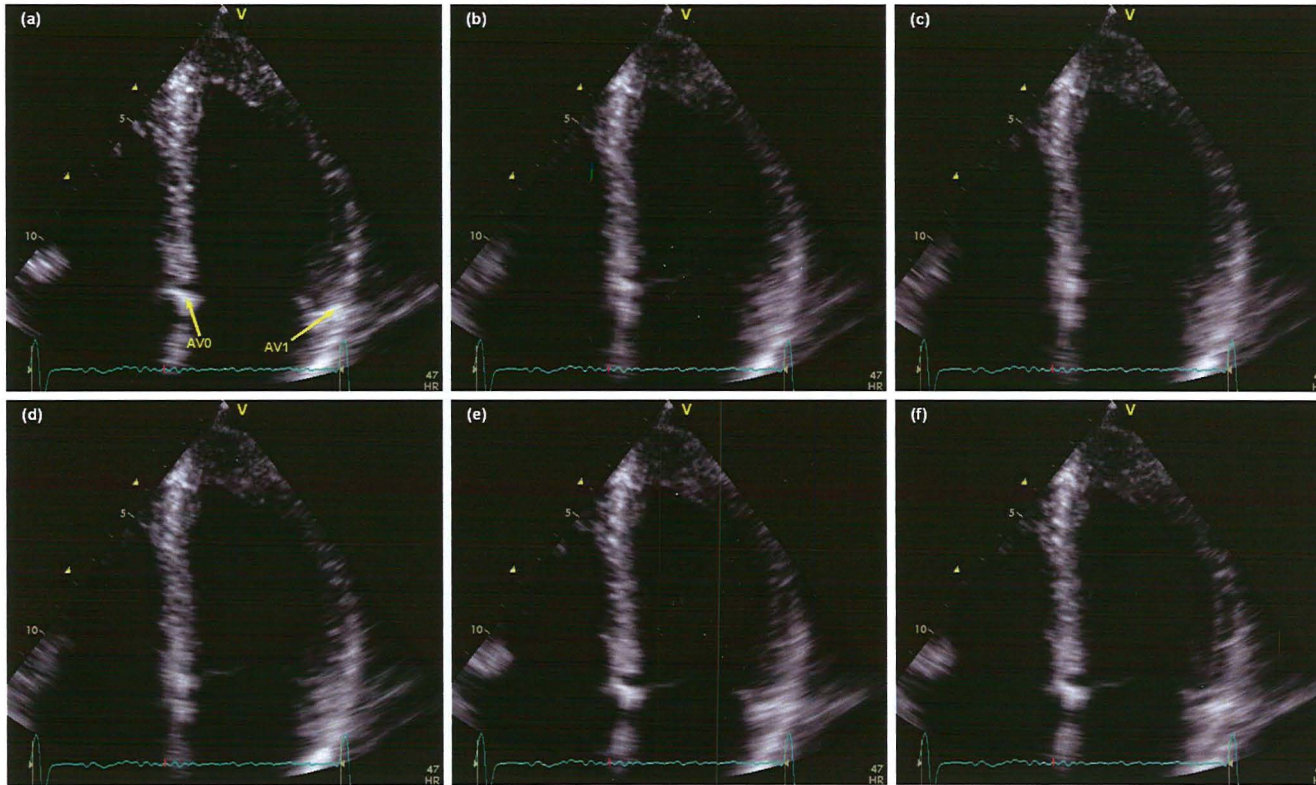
A dilating left ventricle of a healthy adult person is shown in (a). A morphed replacement of this image based on a 50 ms earlier frame and a 50 ms later frame is shown for five different velocity field estimates: (b) No velocity (i.e. linear interpolation), (c) Doppler field estimate (d) Doppler field estimate with smoothing, (e) myocardium field estimate and (f) AV-plane field estimate. The media movie shows these six loop running slow motion. *Thesis comment: The referred movie was published as part of the paper and is available at http://folk.ntnu.no/sveinbr/TviMorphingSamples/six_loops_synchronized.mpg.*
